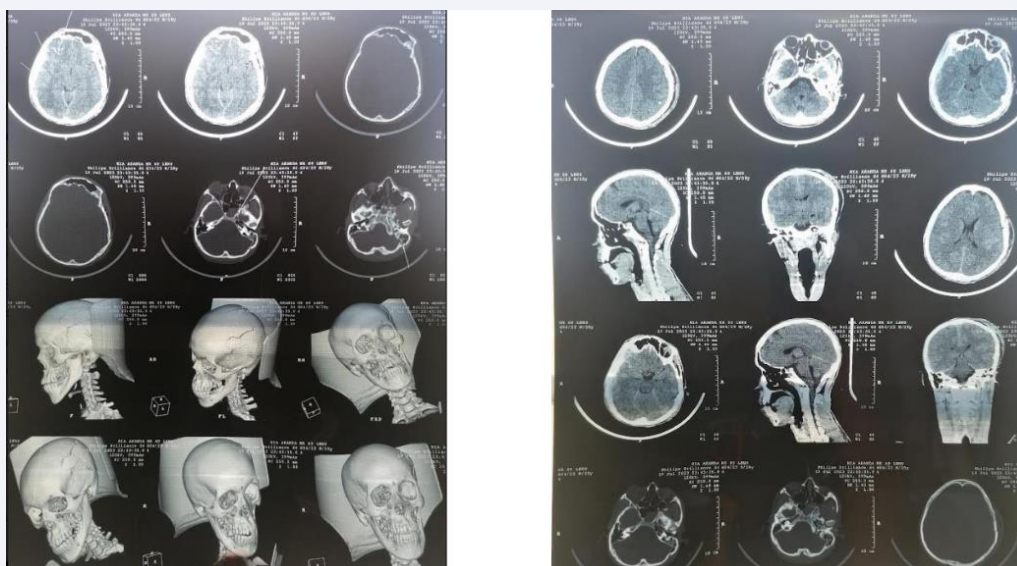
CT scan at admission
